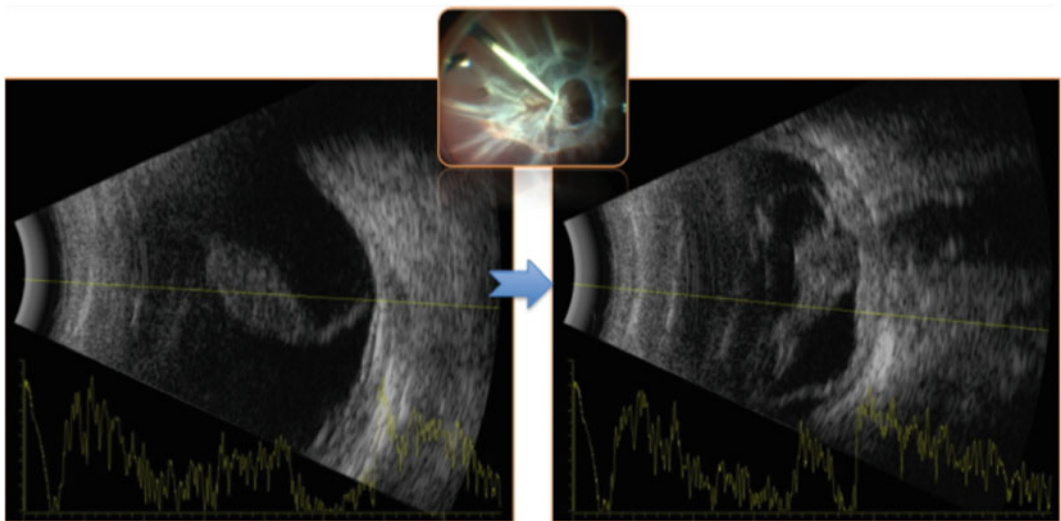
Preoperative ultrasound. Closed funnel RD
